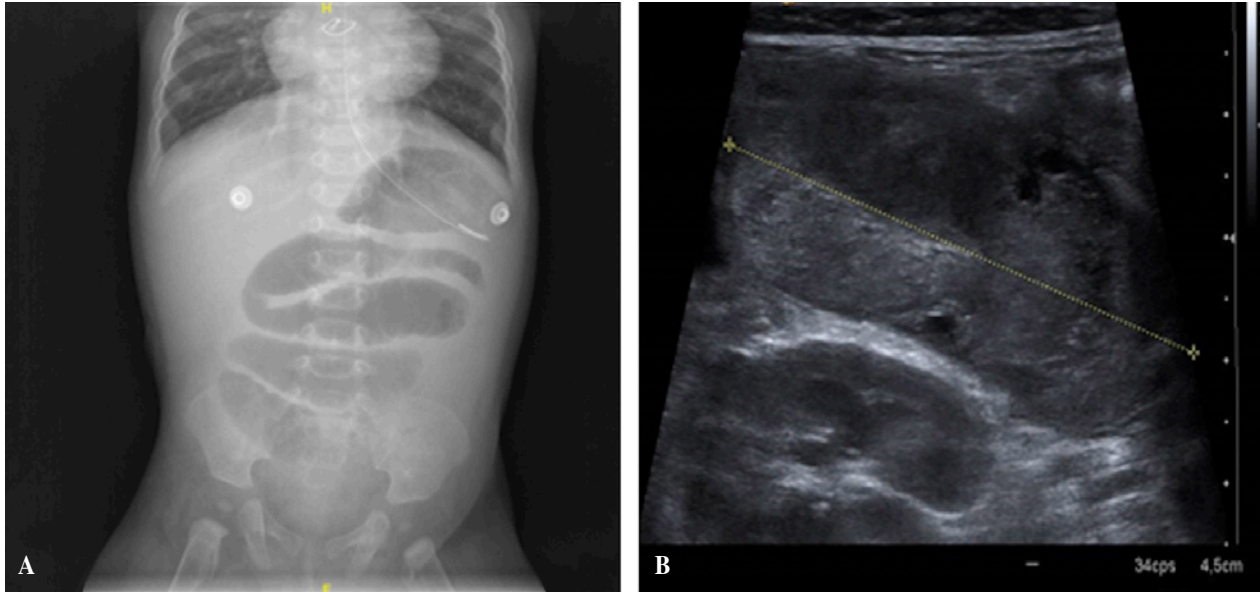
A) Abdominal X-ray: Intestinal obstruction with dilated proximal small bowel loops. B) Ultrasonography: 5cm diameter oval avascular injury at the right flank, with heterogeneous content inside and surrounding hyperemia.
